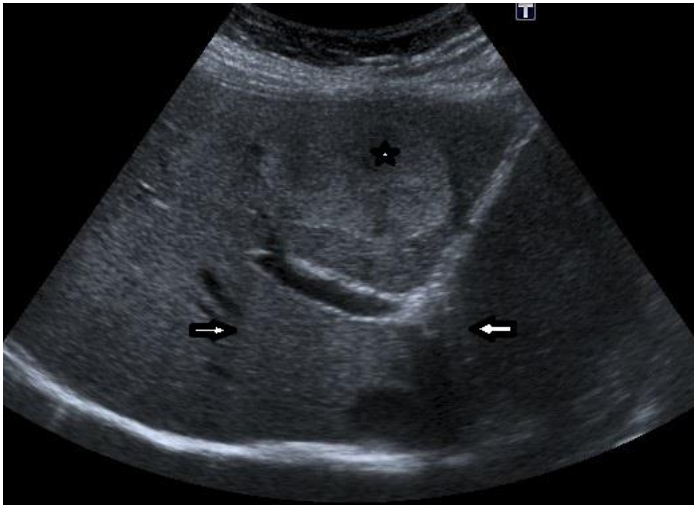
Ultrasonography image shows well-defined hyperechoic solid mass (asterisk) in liver parenchyma. Posterior acoustic enhancement (arrows) is typical for hepatic hemangiomas.
